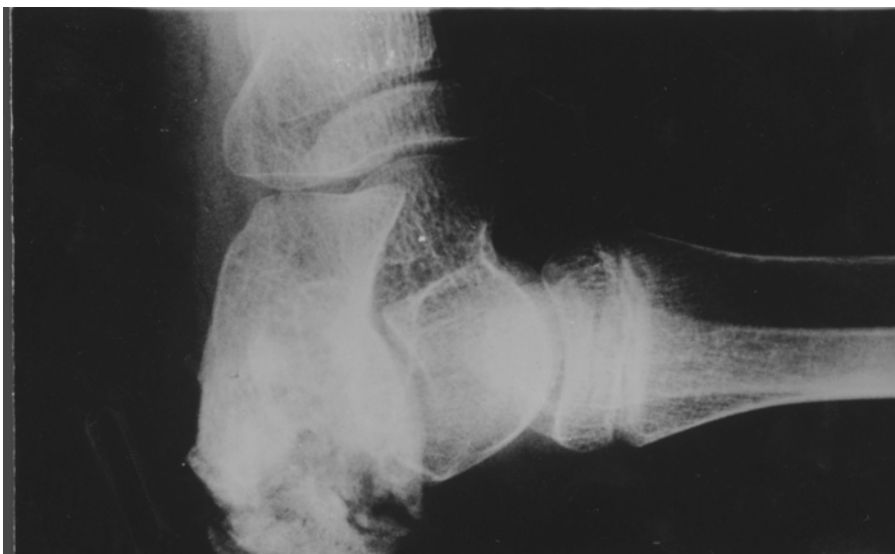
Roentgenogram of right calcaneus with osteolytic lesion.
